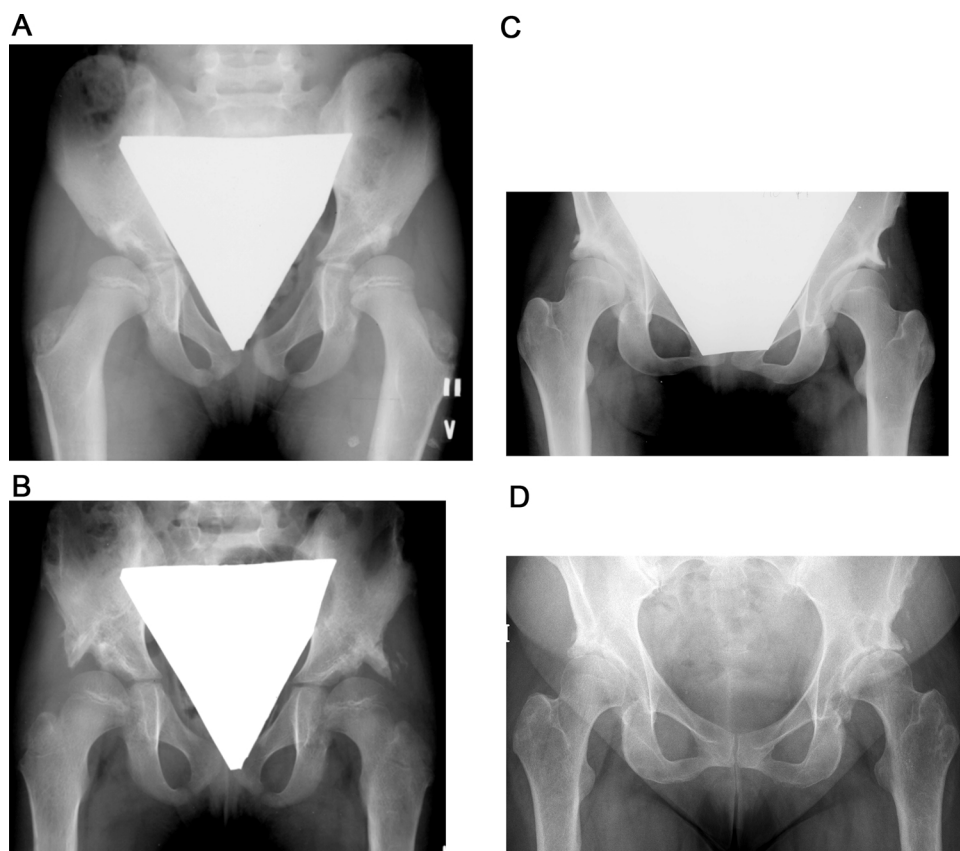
A–D Radiographs of a girl who underwent bilateral Spitzzy shelf operation. (A) Preoperative radiograph at patient age 8.4 years shows bilateral acetabular dysplasia (CE angle 8° in the right hip and 11° in the left). Bilateral Spitzzy procedures were performed at an interval of 3 weeks. (B) Radiograph 3 months postoperatively show that the shelves have been very steeply placed, but considerably increase in femoral head coverage occurred. (C) At age 18 years good remodeling of the shelf has taken place bilaterally. (D) Radiograph 44 years postoperatively shows bilateral osteoarthritis (Harris Hip Score was 76 on the right side and 45 on the left).
